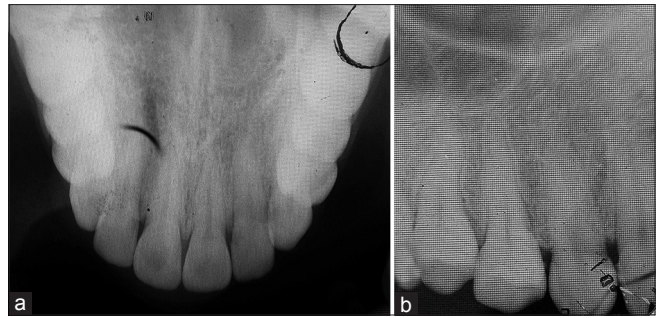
Radiograph of maxilla (front view) showing no bony abnormality or calcification
